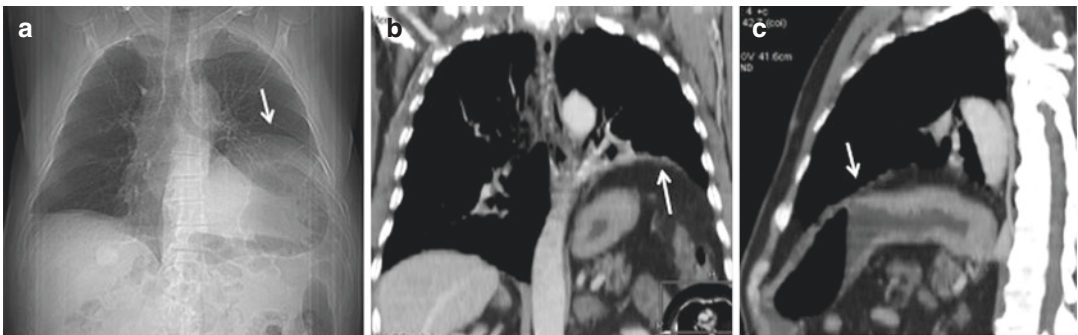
(a) Chest X-ray, (b) coronal, and (c) sagittal MPR images show: elevation of the left diaphragm that is thinned but intact (*arrows*); no dependent viscera sign or
